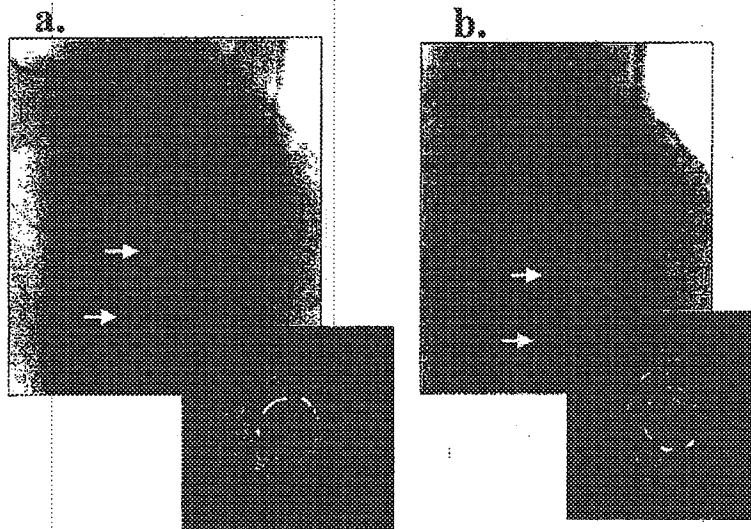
Acute angiographic and intravascular ultrasound (IVUS) results obtained after cutting balloon angioplasty (CBA) for in-stent restenosis (ISR) in left circumflex artery. (a) Preintervention IVUS image shows complete neointimal filling of the lumen in the stent (lumen cross-sectional area 1.3 mm²). (b) Final result following CBA with 2.5-mm balloon (lumen cross-sectional area 6.0 mm²).
